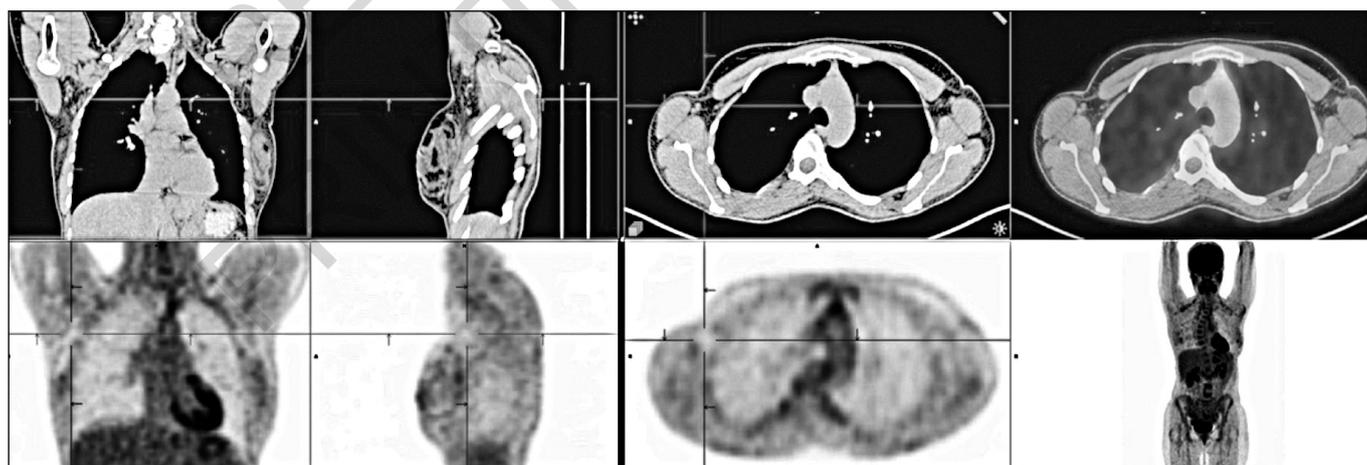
PET-CT IMAGE Axillary lymph nodes were normal in the preoperative staging PET-CT examination of a 44-year-old patient diagnosed with ER (+), PR (-), Her-2 (-), Grade III Invasive ductal carcinoma detected by routine screening in the left breast. When sentinel lymph node biopsy was positive, axillary dissection was performed and metastasis was detected in three of 18 lymph nodes. (ER; Estrogen receptor expression status, PR; Progesterone receptor expression status, Her-2; Human Epidermal Growth Factor Receptor 2 status, PET-CT; 18-fluorodeoxyglucose positron emission tomography/computed tomography)
